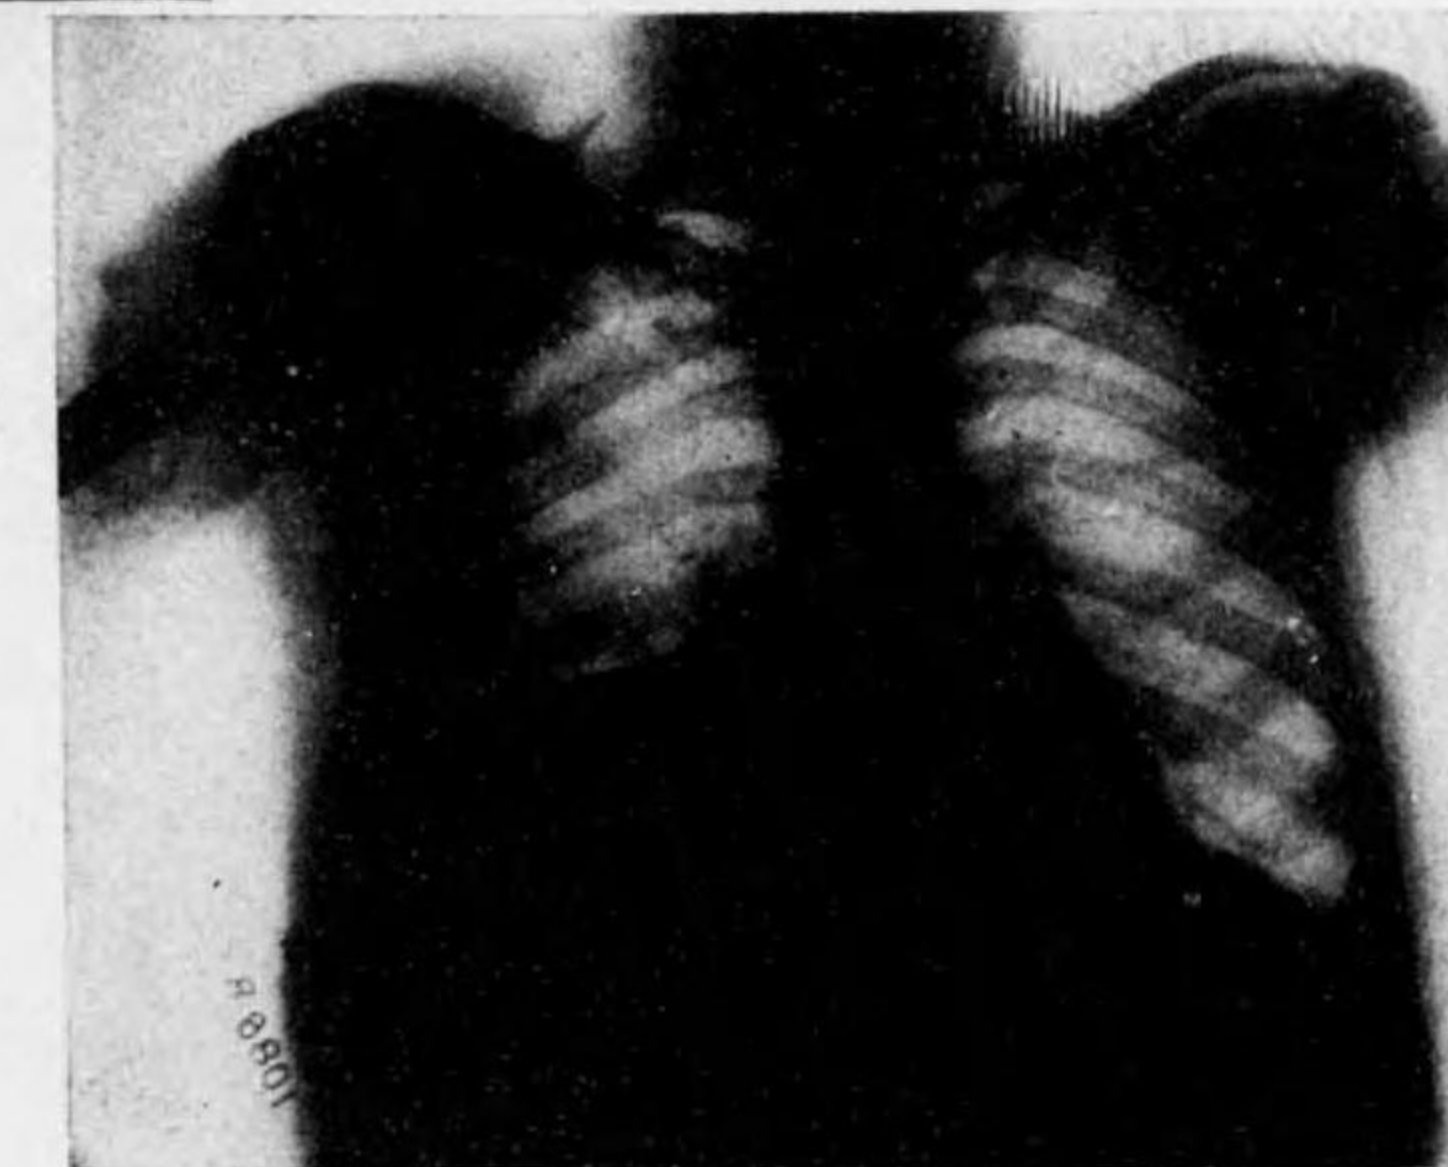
Case XVII, boy of 8; 9 days ago operated on tonsils. X-ray taken on 9/13/24 in prone position.
